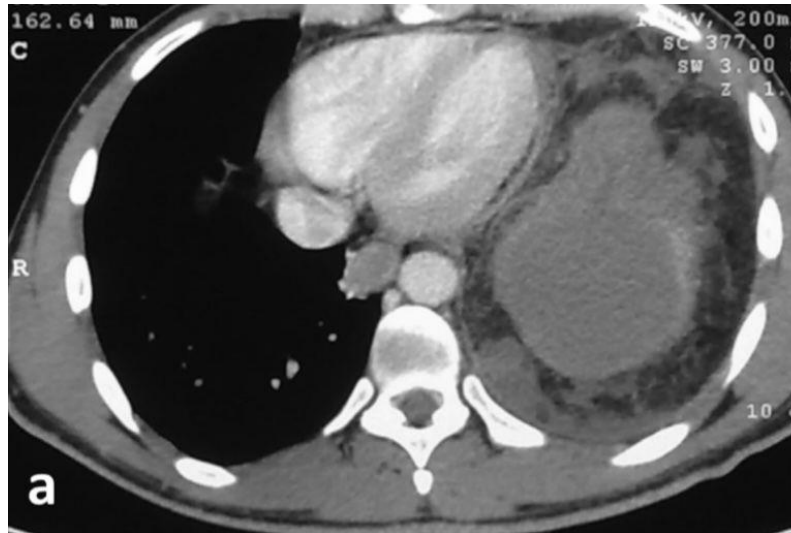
CT scan showing diaphragmatic rupture
